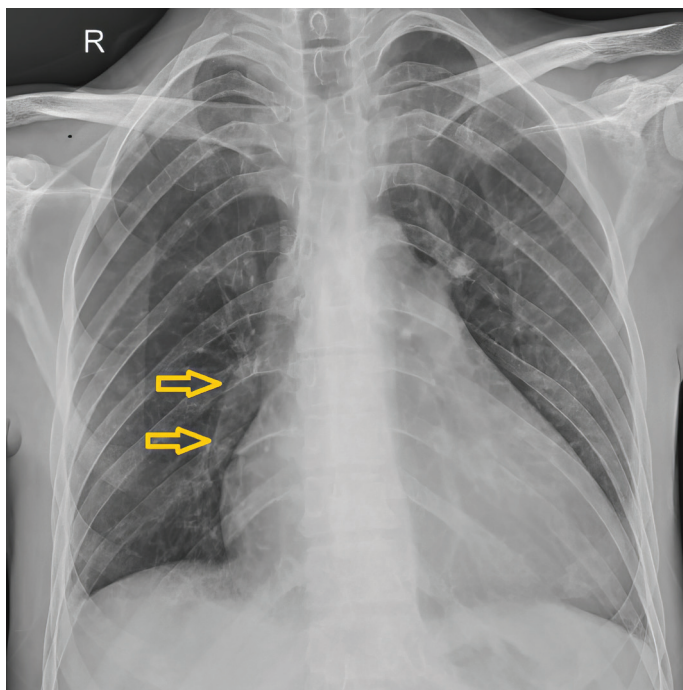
In a posterior-anterior chest radiograph, there is marked enlargement of the right hilum and right main pulmonary artery.
